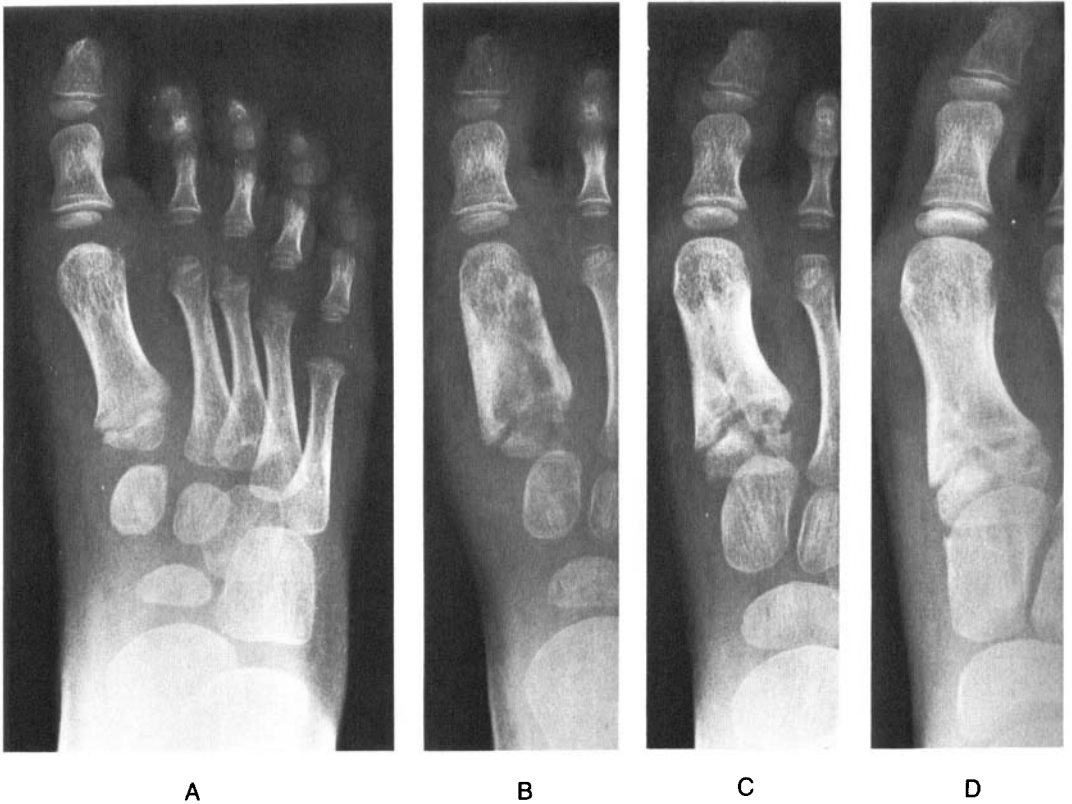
A-D. Serial radiographs of patient no. 13, a girl who developed osteomyelitis of the first metatarsal at age 4 years.
